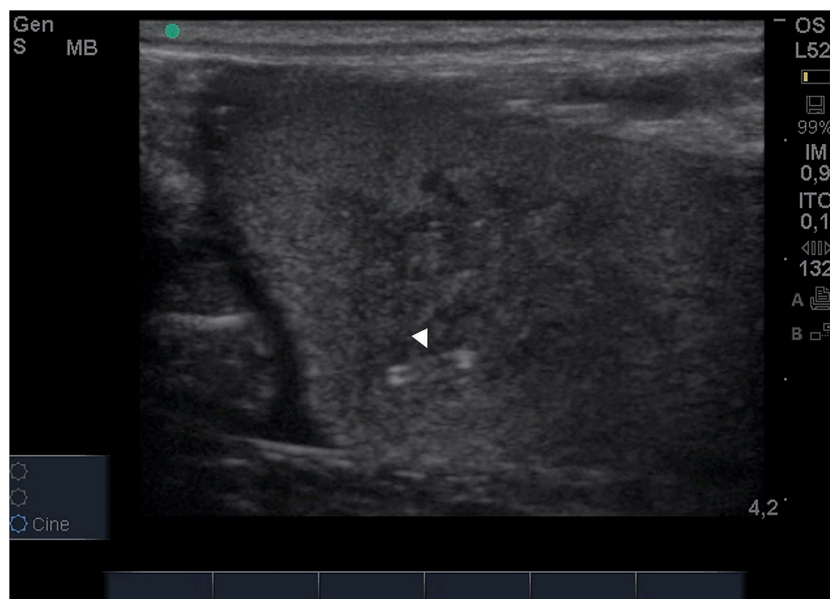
The intraabdominal testes imaged with transrectal ultrasonography. Two parallel hyperechoic lines were seen in a hypo-anechoic area (arrowhead).
